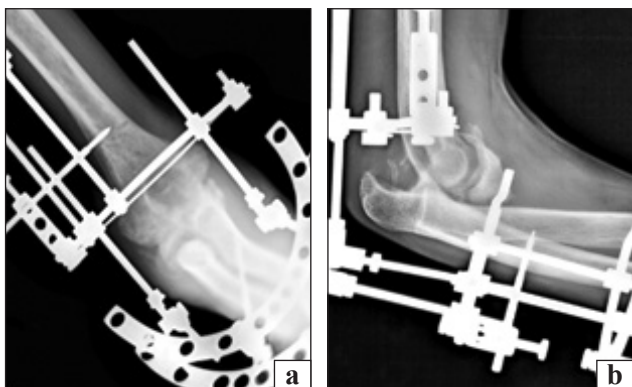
Radiographs in direct (a) and lateral (b) projections of the elbow joint after the first surgical intervention
